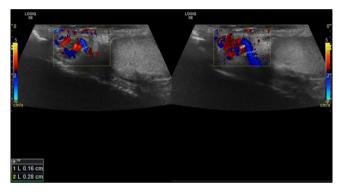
Doppler ultrasound examination showing the pampiniform plexuses and their measurements. The veins are colored in squares surrounded by a thin yellow line, and the image on the left shows a normal vein, and the image on the right shows a dilated vein (vein diameters 1.6 mm and 2.8 mm in the lower left corner, respectively).
